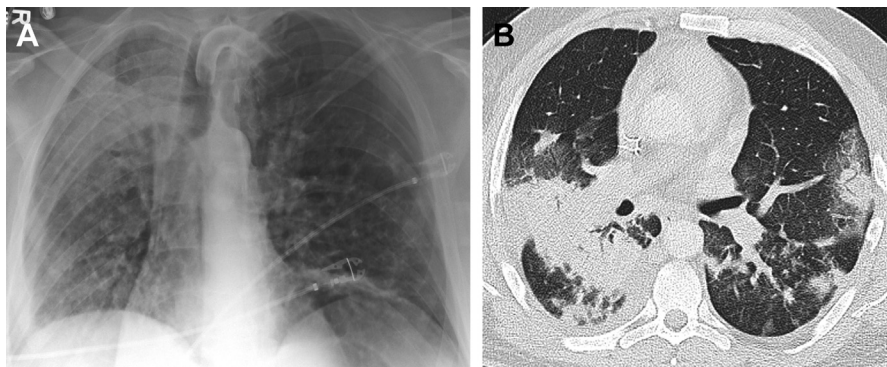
Forty-four-year-old man with pseudomonas pneumonia. Herpes virus demonstrated on bronchoscopy performed on during after 2 weeks of hospitalization. (A) Frontal chest radiograph shows a right upper lung consolidation, more suggestive of bacterial pneumonia. (B) Axial chest CT demonstrates extensive consolidation in the superior segment of the right lower lobe, and additional smaller foci of consolidation in the left lower lobe. The multifocal consolidation is most consistent with a bacterial pneumonia. Presence of HSV virus on bronchoscopy may be incidental and not contribute significantly to the patient's pneumonia.
